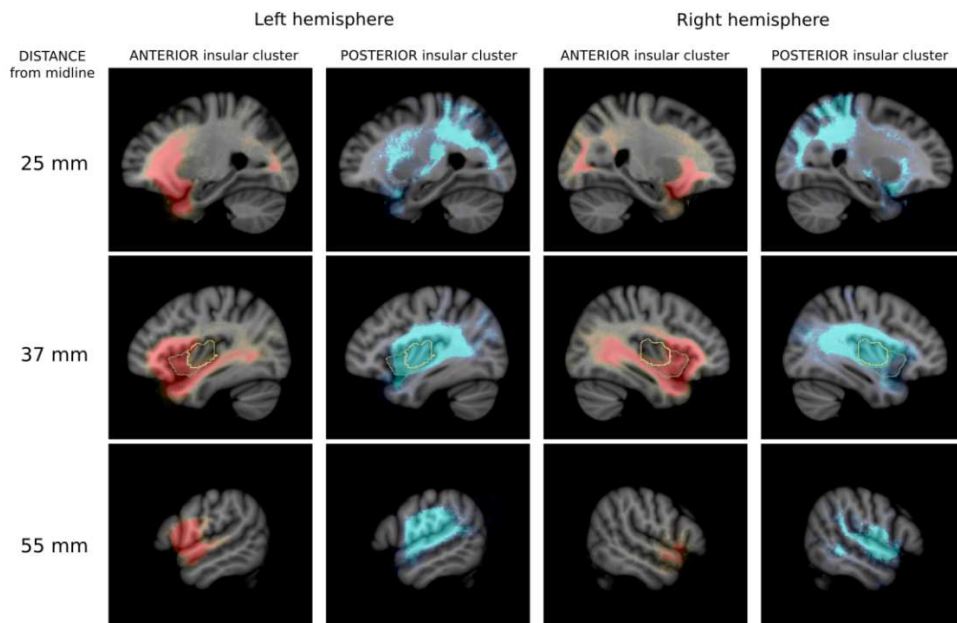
Cross-sectional images demonstrating the fiber tract anatomy of the connectivity-based insular subdivisions (specific aim A/2), overlaid on a standard neuroimaging MRI T1-weighted template (MNI152). Connection probability estimates ($n=40$, averaged) from the anterior and posterior insular subdivision depicted in three different sagittal images. The distance from the midline in stereotactic space is given.
